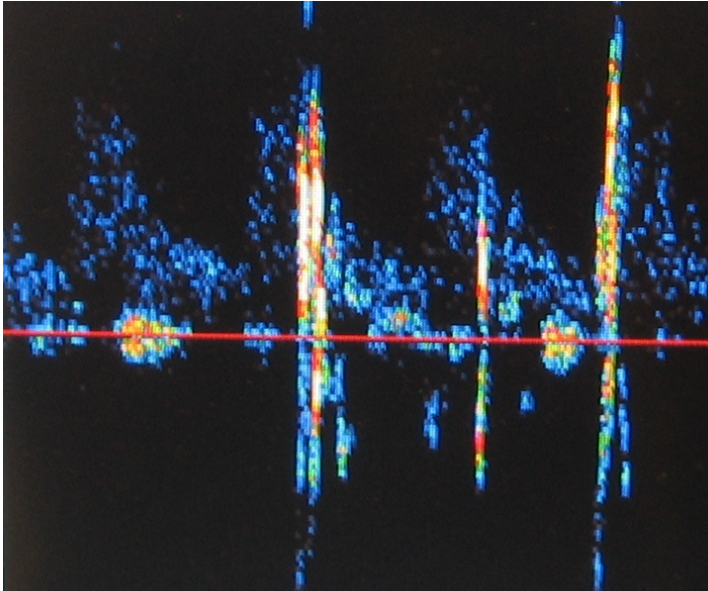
Pulsating transcranial Doppler blood flow velocity signal including several high-intensity transient signals from the insonated middle cerebral artery.
